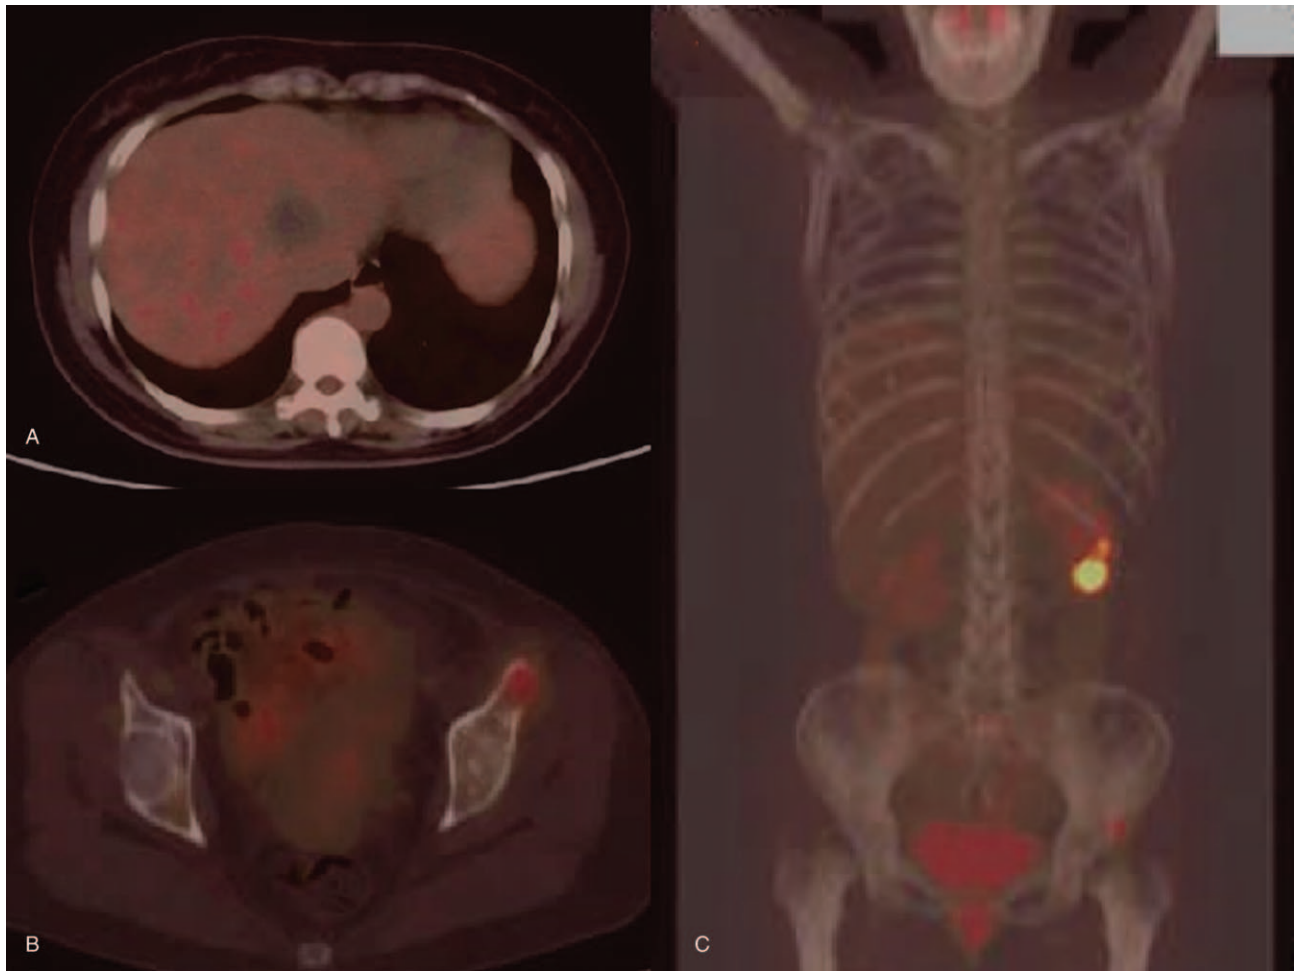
PET-CT demonstrating hepatic and skeletal metastases, (A): CT scan for intrahepatic multiple FDG hypermetabolism metastases; (B): CT scan for FDG hypermetabolism metastases of the left ilium; (C): abdominal orthostatic plain film for hypermetabolism metastases. CT=computed tomography, FDG=fluorodeoxyglucose, PET=positron emission tomography.
